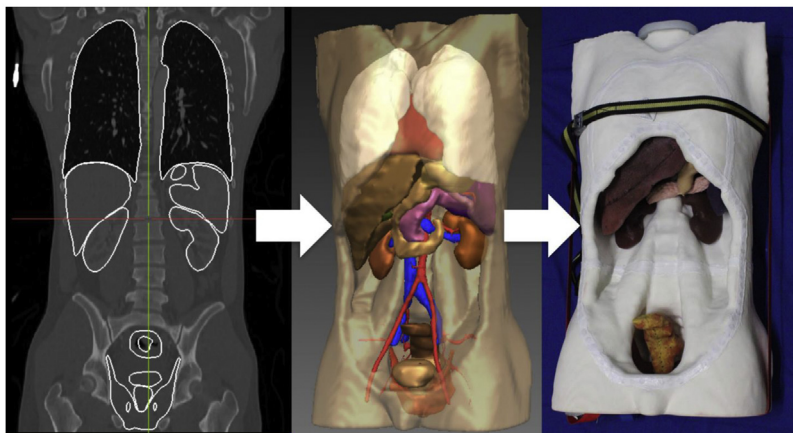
OpenHELP with visceral organs. Left: Segmented organs on the computed tomography; Middle: Computer visualization of segmented organs; Right: Materialized model with organs. The open source project is accessible at www.open.cas.org. Courtesy: Dr. H. Kenngott, University Hospital Heidelberg.
